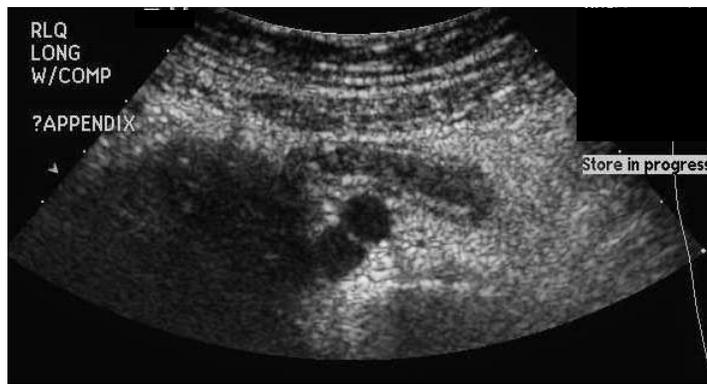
Ultrasound showing thickened appendix in an 18-month-old child with vomiting.
